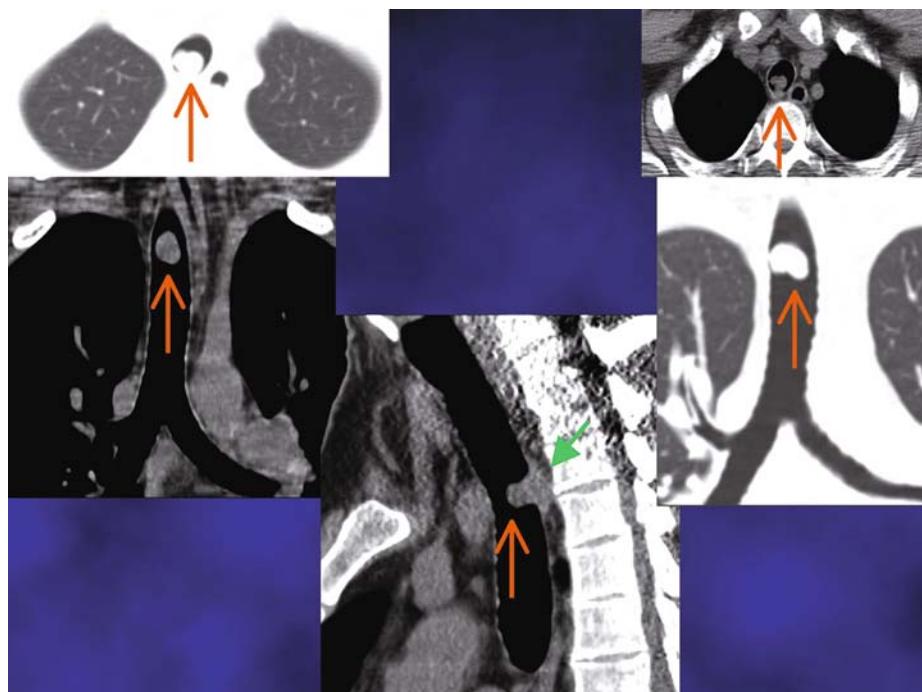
Glomus tumors of the trachea. Computed tomography images showing endoluminal and extramural extent of the tumor (from Nadrous et al., with permission). See chapter reference for complete citation.
